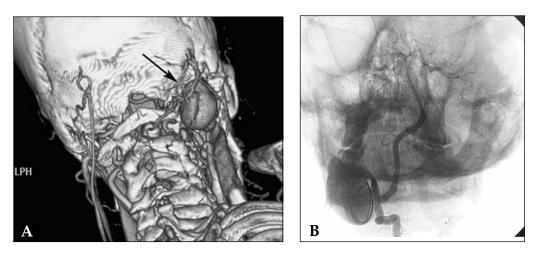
A 50-year-old man presented to the emergency department with complaints of an enlarging pulsatile mass behind his right ear with an associated bruit. CT (A) revealed a large pseudoaneurysm of the right vertebral artery, which was confirmed by angiography (B). Microcatheter delivery of 0.018" coils into the aneurysm sac led to thrombosis of the pseudoaneurysm, with absence of flow confirmed by duplex at follow-up. In this case, stent-grafting was felt to be a poor option given the location of the pseudoaneurysm in the distal vertebral artery. Coiling of the vertebral artery proximal and distal to the injury would be the fallback procedure if the sac had failed to thrombose.
